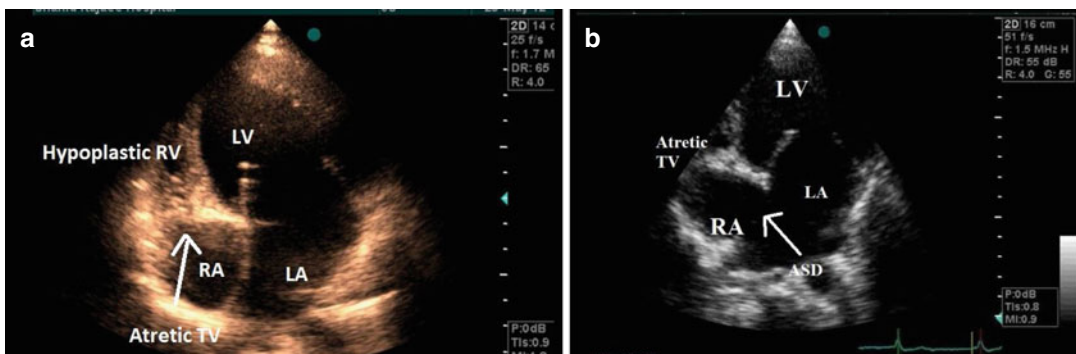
(a, b) Transthoracic echocardiography in four chamber view showing tricuspid atresia (TA) as a fibromuscular tissue in place of TV, associated with hypoplastic
